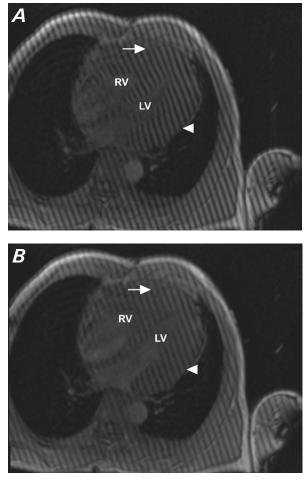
Cardiac magnetic resonance images in A) systole and B) diastole show tethering of the left ventricular (LV) lateral wall (arrowheads) and the right ventricular (RV) apex (arrows) with contrasting tag lines not breaking at the RV myocardial–pericardial junction. In patients without cardiac disease, tag continuity is disrupted during cardiac contraction because of shear motion between the visceral and parietal layers.
